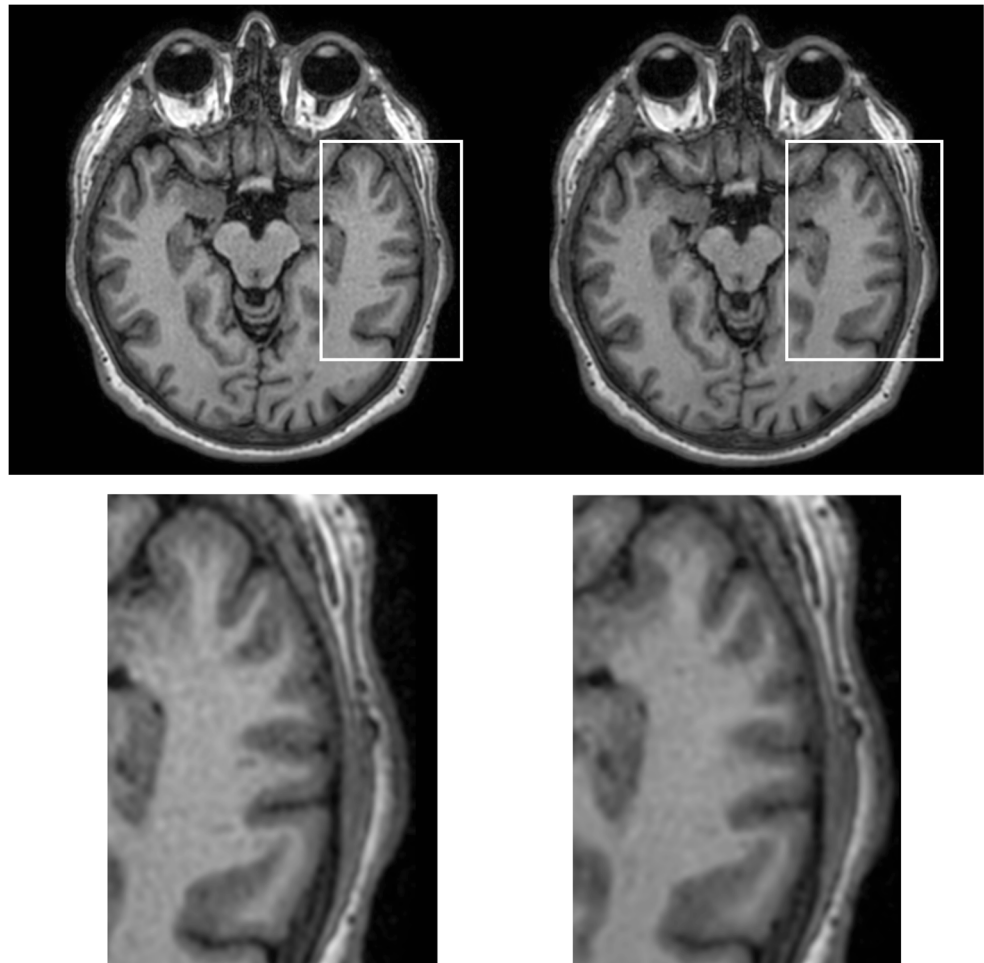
Examples of images obtained with conventional (left) vs CS sequences (right) for all the applications tested, i.e. a Brain 3D T1 Gd (transverse reformat). b Brain 3D FLAIR (transverse reformat). c Heart cine. d Bile duct MRCP trig (maximum intensity projection). e Liver 3D
